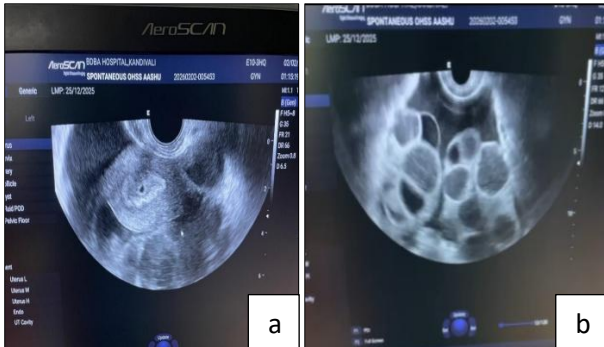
(a and b): Ultrasonographic imaging revealed bilateral ovarian enlargement with multiple contiguous thin-walled cysts containing anechoic fluid.
